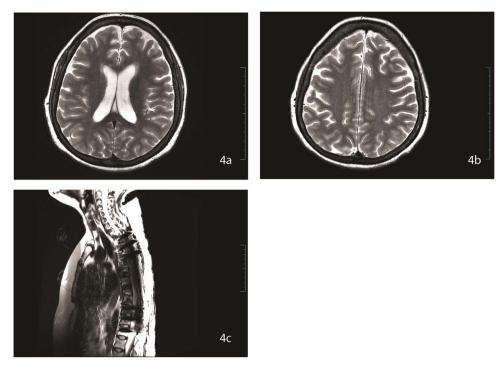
MRI brain and spine after 1 year revealing complete resolution of lesions.
